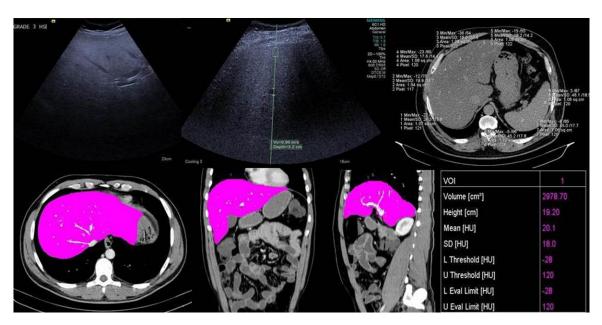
US, SWE, non-contrast CT images, and contrast CT MPR images. A 48-year old male patient, existing with grade 3 hepatosteatosis; LAI-30, the mean value of SWV 1.01 m/s, the liver volume 3018.14 cm³, the liver size 19.2 cm.
